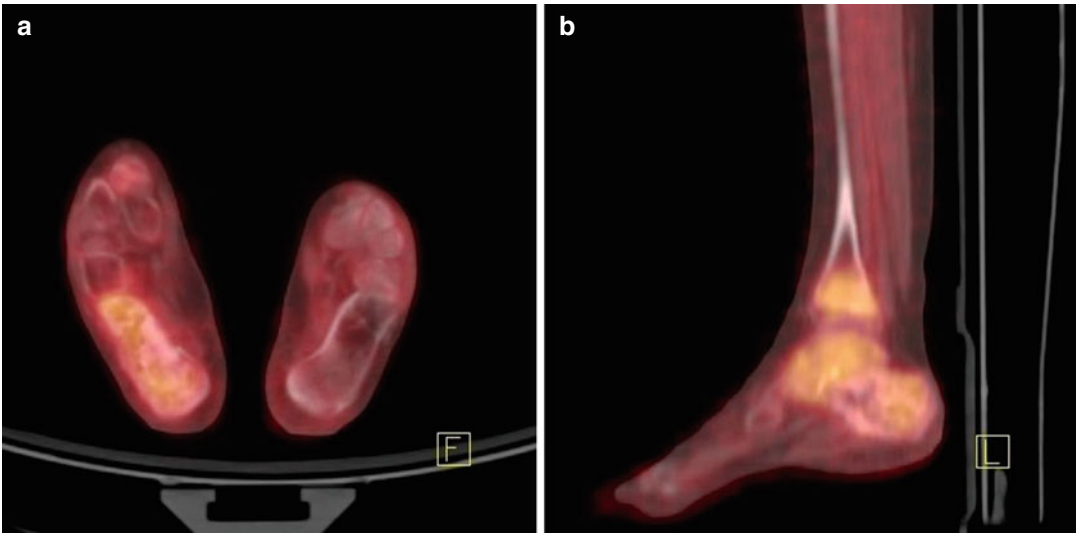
Axial and sagittal PET/CT images (a, b) show lytic and sclerotic areas in the right heel with increased radiopharmaceutical uptake (SUV_{max} 3,3)
